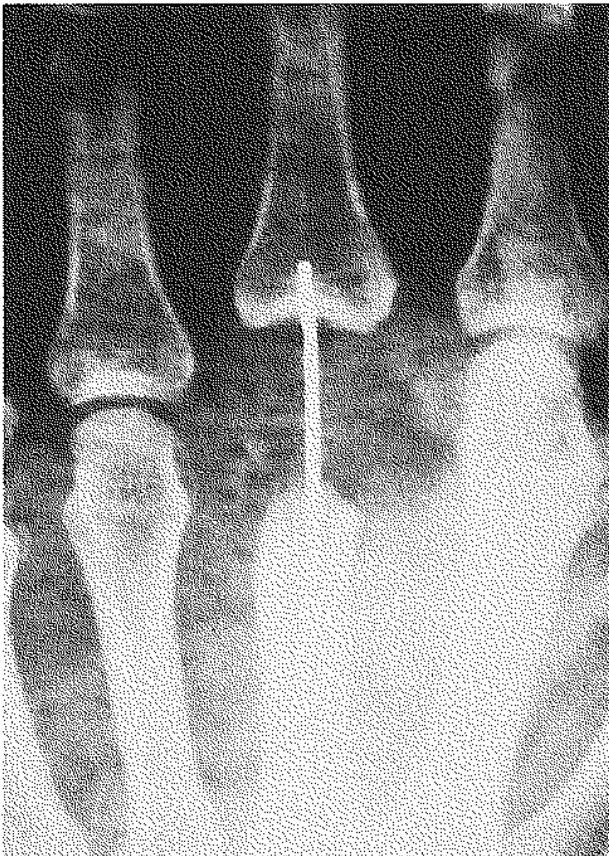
Radiograph of the injured hand. The distal fourth of the third metacarpal is missing.
